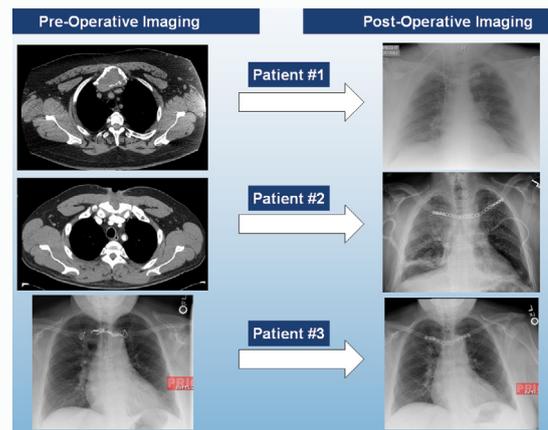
Comparison of pre-operative imaging (left panels) and post-operative imaging (right panels) for each of the 3 patients. The left panels for Patients #1 and #2 are axial images from their pre-operative computerized tomography scans showing the manubrial tumors, while the left panel for Patient #3 is a pre-operative posterior-anterior chest radiograph showing the daisy-chained loops of sternal wire, with the broken loop attached to the patient's left clavicle. Right panels for all 3 patients are post-operative chest radiographs showing the interclavicular titanium plates.
